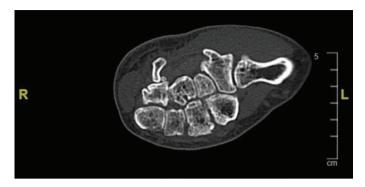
Cross-sectional CT at the level of the right carpal bones clearly showing overlapping.
